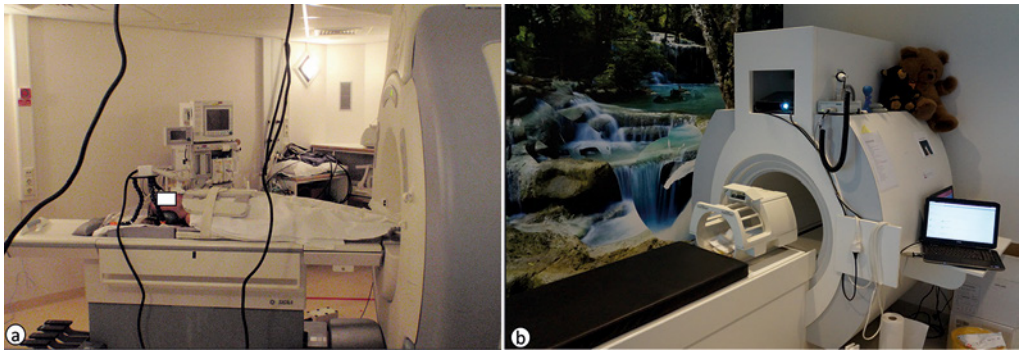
MRI compatible spirometer set-up. CF patient in a 1.5 T MRI with MR compatible spirometer setting. (1a) A plastic adjustable tripod holds the mouthpiece that is connected through a plastic black corrugated tube to the control computer at the scanner operator's side. (1b) Mock MRI scanner is used to train the pediatric patient before the actual MRI scan. The mock MRI scanner can reproduce the noises that the patient will hear inside the real MRI environment. The mock scanner also contributes to reduce the anxiety level of the patient before the real examination.
